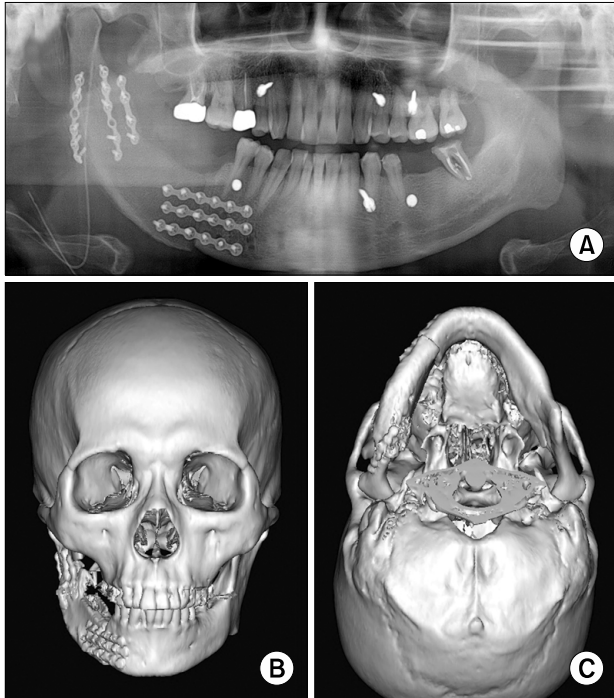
Postoperative 3-dimensional computed tomography reconstructed images and orthopantograph showing accurate replication of virtually surgical planned mandibular reconstruction with deep circumflex iliac artery flap. Note the restoration of the mandibular continuity and esthetic contour acquired after surgical application of virtual surgical planning.
